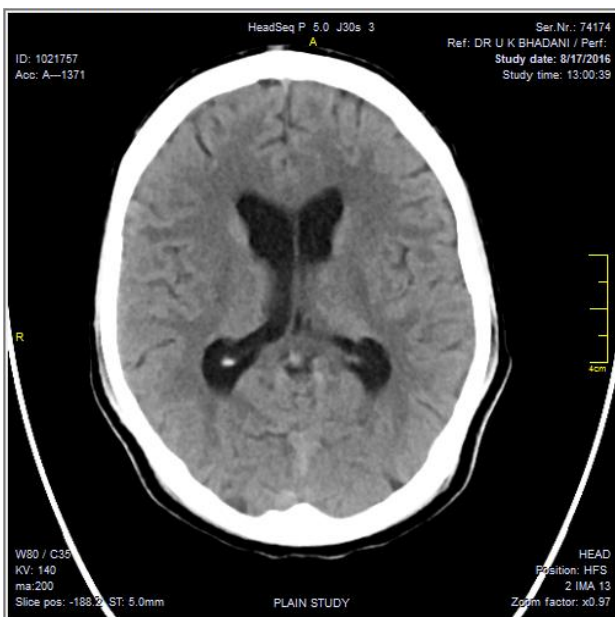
CT scan of patient with subarachnoid haemorrhage after dural puncture at the time of discharge without neurological sequelae.
